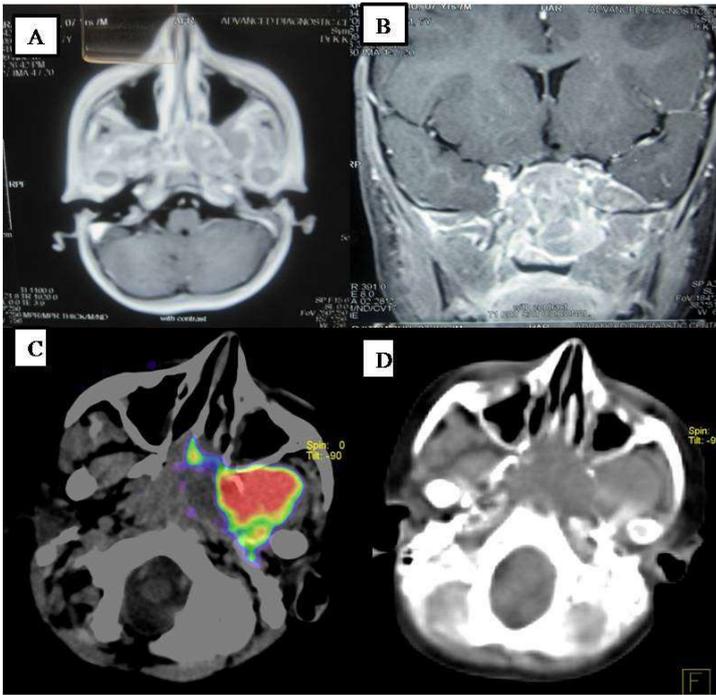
(A) CECT heads & neck of a 7 yrs old child showing an enhancing lobulated mass involving the Lt masticator space, nasopharynx , sella & parasellar area. (B) MRI (C) transaxial PET/CT scan of the child showing mass involving Left masticator space nasopharynx, sphenoid sinus with intracranial extension & causing erosion of Lt pterygoid plate. Focal area of hyper metabolism in the region of Lt masticator space & rest of the mass shows hypometabolism.
